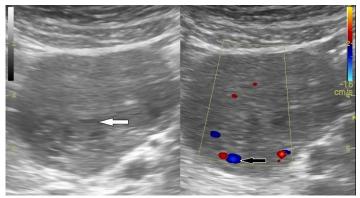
Ultrasound shows heterogenous hypoechoic solid mass with few cystic areas (white arrow) in the left adnexa whereas the left ovary is not visualized separately; on color Doppler ultrasound, the left adnexal lesion shows internal vascularity (black arrow)
